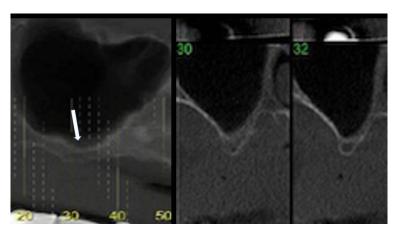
CBCT views showing minimal crestal bone height insufficient for placement of implants without sinus augmentation.
